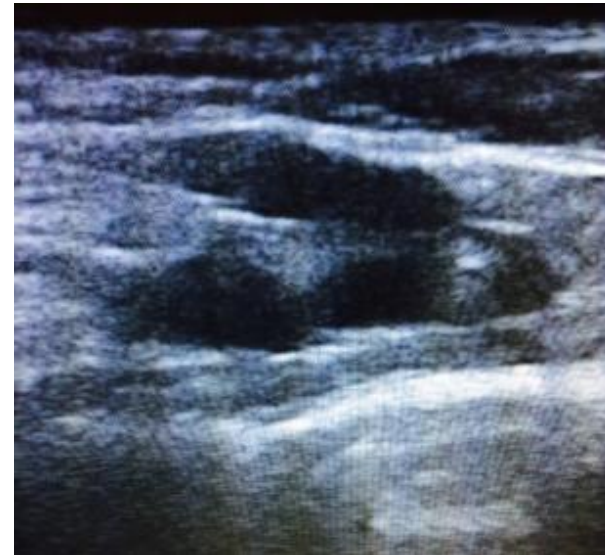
Ultrasound image of a right subclavian cannulation. The probe is placed at the inferior margin of the clavicle (*top right*), and the subclavian vein is imaged (*top left*). The needle is placed directly under the curved portion of the probe, entering at a 45° angle (*top right*). The guidewire is seen entering the subclavian vein. Subclavian placement is confirmed because the needle and wire entry are medial to the lateral margin of the first rib (*bottom left*). This method allows for needle entry within 1 to 2 cm from the clavicle (*bottom right*).
